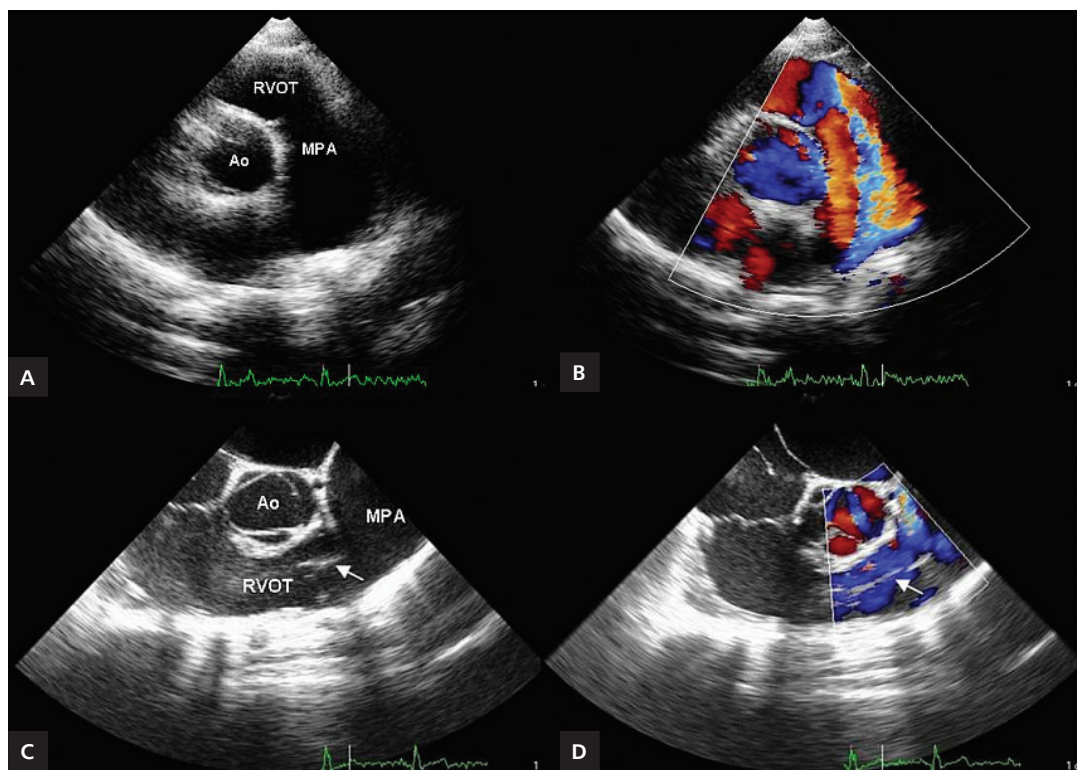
Two-dimensional transthoracic echocardiography (2D TTE) short axis view showing aneurysmally dilated main pulmonary artery (A) and 2D colour Doppler TTE revealing bidirectional flow in main pulmonary artery (B). Two dimensional transoesophageal echocardiography (2D TEE) parasternal short axis view showing aneurysmally dilated main pulmonary artery and a membranous structure (arrow) dividing pulmonary artery into two parts (C) and 2D colour Doppler TEE demonstrating a turbulent flow in this area (arrow) (D); Ao — aorta; MPA — main pulmonary artery; RVOT — right ventricle outflow tract
